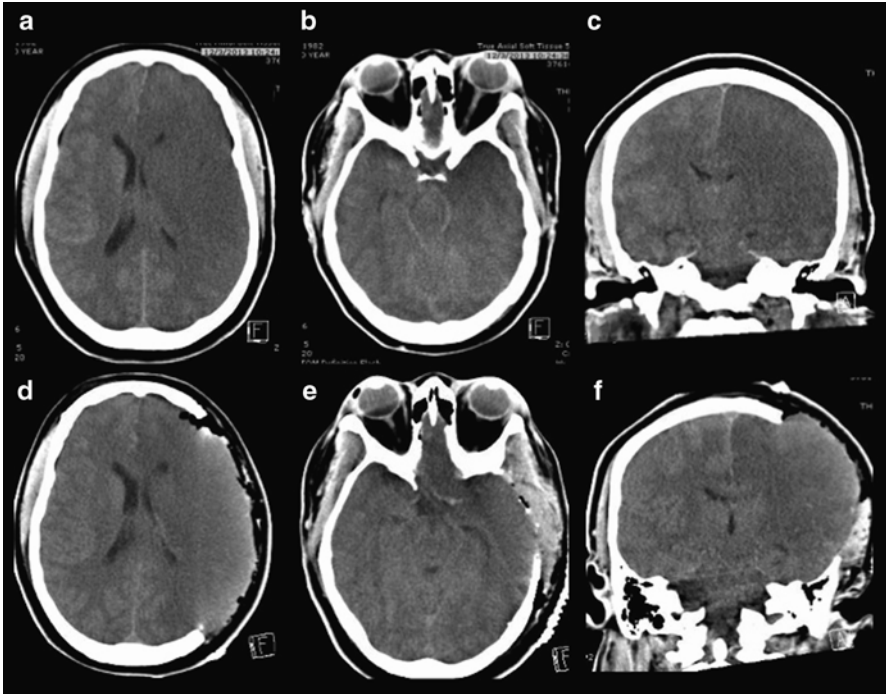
Malignant MCA infarction requiring decompressive craniectomy. Computed tomography (CT) shows malignant right middle cerebral artery (MCA) infarction with extension into the temporal lobe (a–c). Post-surgical resolution of subfalcine herniation with overlying scalp expanded to accommodate expanding brain (d–f)
